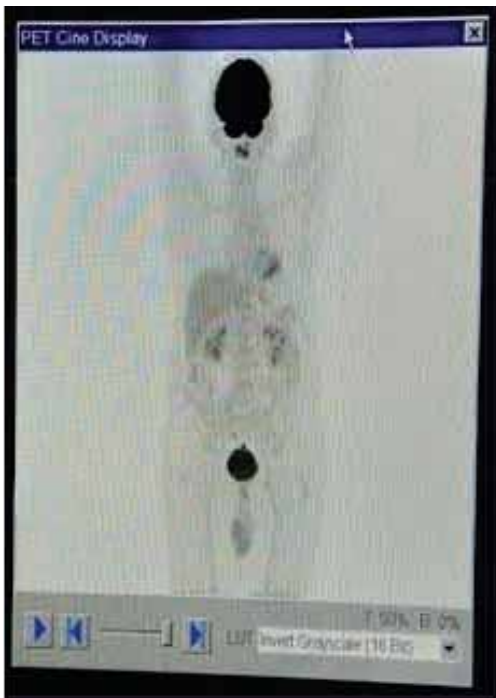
PET-CT Scan of ^{18}F -FDG carried out in North City Centre, Kolkata
